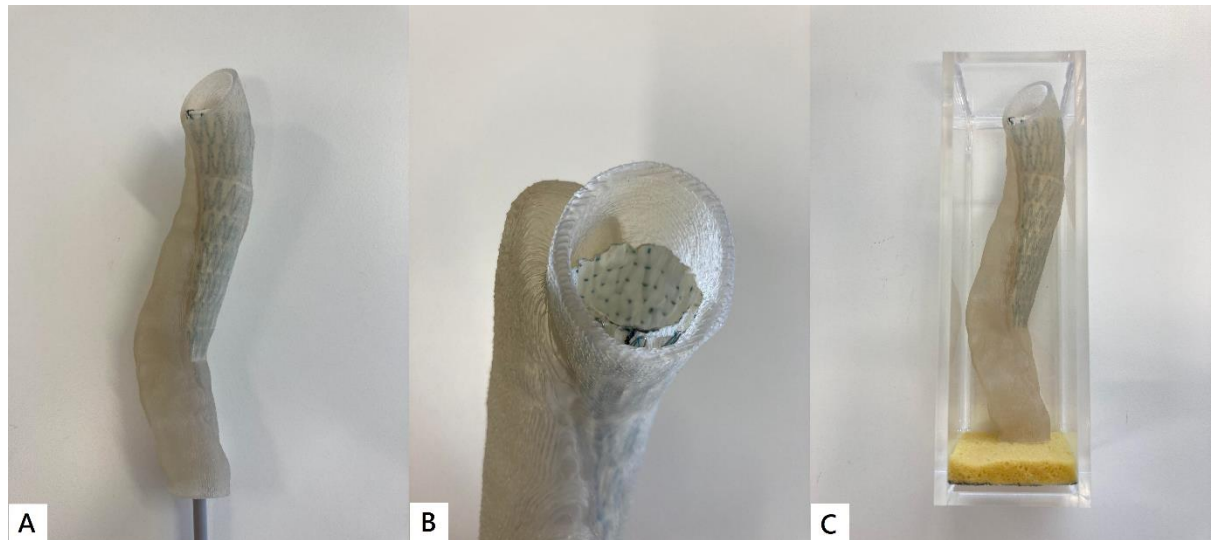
Stent graft deployment of 3D printed model. A: Translucent model makes stent graft deployment easier. B: Axial view from proximal descending aorta. C: Model was placed in an acrylic box for CT scanning.
